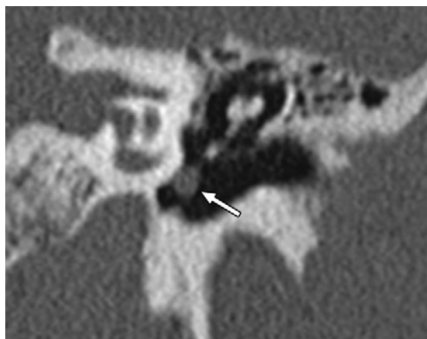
Coronal CT image of glomus tympanicum demonstrates a small, rounded nodule in the middle ear abutting the cochlear promontory (arrow). (Juliano ,2013).
